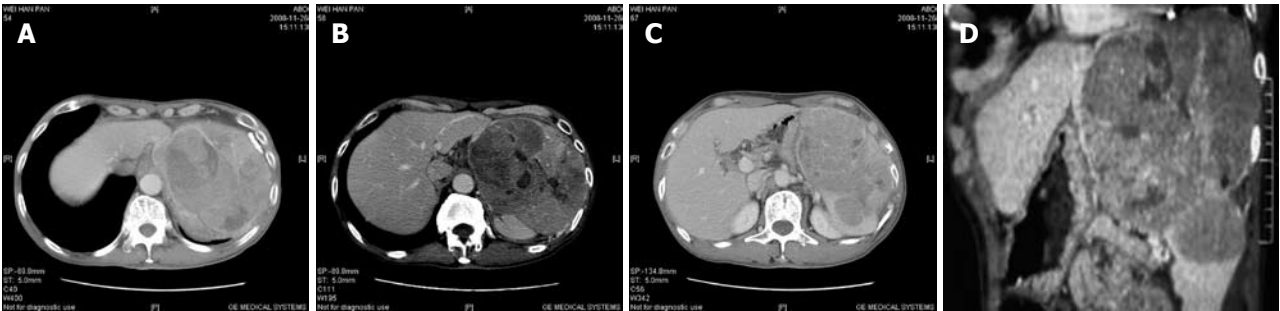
CT scan in abdomen showing a mass tumor between left hepatic lobe and spleen directly involving the upper pole of spleen and almost making no invasion into the liver (A-D).
